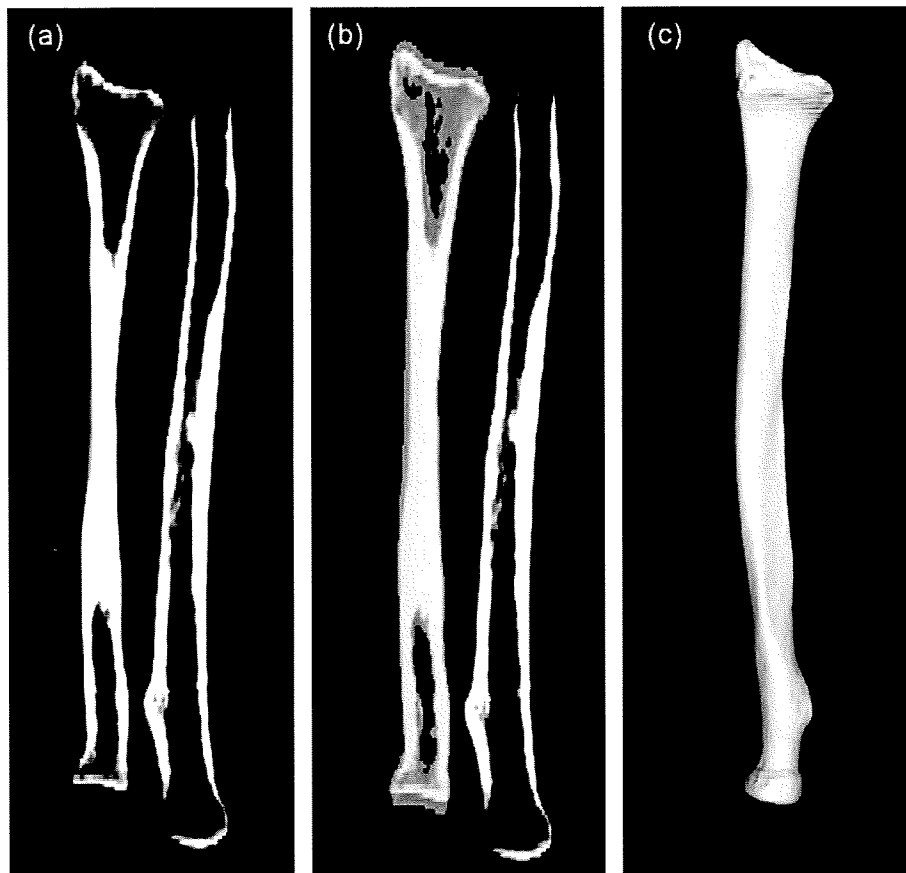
With an image obtained from CT reconstruction (a), the malunited bone was segmented (b) and a 3D surface model was constructed using an original computer program (c)
